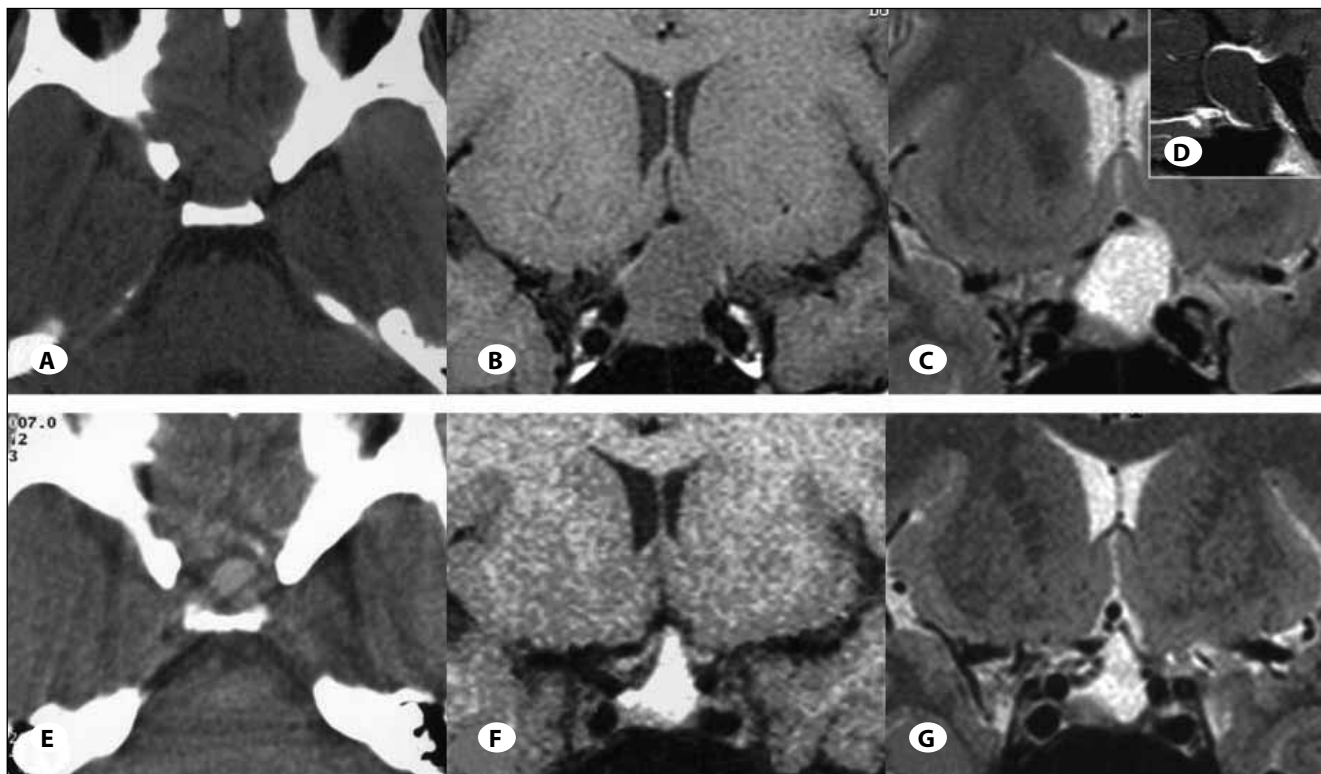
The initial A) CT and coronal B) T1-, C) T2 -weighted images at a neighboring physician. D) Sagittal postcontrast T1-weighted image. Three-week follow-up E) CT and coronal F) T1 -, G) T2 -weighted images.
